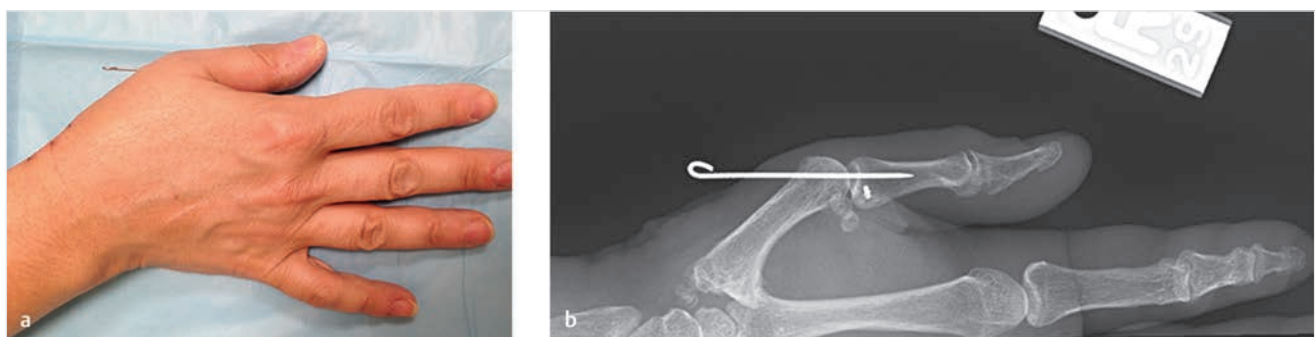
One-month postoperative (a) photograph and (b) X-ray after carpometacarpal (CMC) arthroplasty and MCP volar plate arthroplasty.
